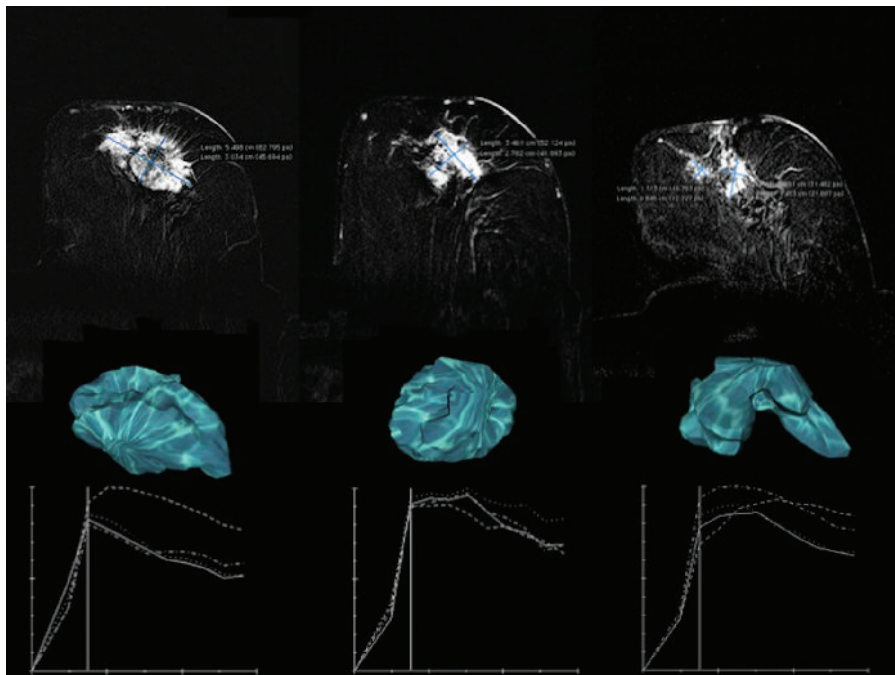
DCE-MRI. Analysis of a patient on three scheduled MRI examinations. Initial target lesion size was 5.5 cm. After the two cycles of neoadjuvant chemotherapy (NACT), the lesion decreased by 38.2% and upon the completion, the lesion decreased by 41.8%. The initial volume of 41.1 cm³ decreased by 63.8% after the second cycle of NACT and by 90.5% after the completion of NACT. The regression pattern after the doxorubicin-cyclophosphamide regimen was concentric. After the taxane-based chemotherapy, the tumor regression pattern was dendritic. Following the washout time intensity curve, the curve-flattening phenomenon occurred after the two cycles and upon the completion of NACT.
